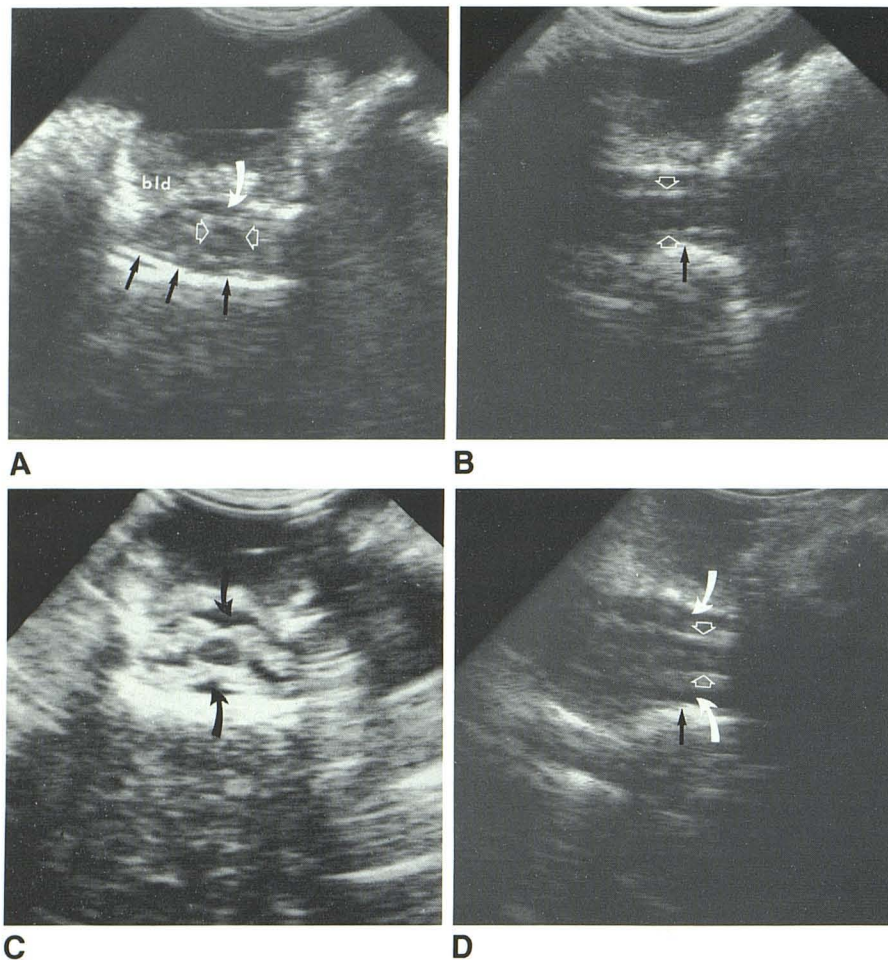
Adequate decompression at conus level after HRI. A, Transverse intraoperative sonogram before HRI. Compression of thecal sac at conus level by displaced bone fragment (*straight arrows*), which is greater on left. Conus (*between open arrows*) is seen as relative hypodensity in middle of thecal sac. Individual nerve roots surrounding conus can be seen. Small amount of CSF (*curved arrow*) is present underneath dorsal dura; no CSF is seen ventrally. Large amount of blood (*bld*) is seen layering on top of dura. B, Midline longitudinal sonogram. Displaced bone fragment (*arrow*) is close to but does not compress ventral surface of conus (*between open arrows*). Intact central echo in middle of conus is seen. Transverse (C) and midline longitudinal (D) sonograms after HRI. CSF (*curved arrows*) is seen around entire conus and adjacent roots. This is considered adequate decompression, even though some bone fragment displacement (*straight arrow*) and slight vertebral malalignment is still evident. Conus is clearly seen as hypoechoic structure in center of spinal canal in C and is outlined by *open arrows* in D. Improvement in alignment is best appreciated when distance between displaced bone fragment and ventral surface of conus is compared in pre- (B) vs. post-HRI (D) sonograms.
